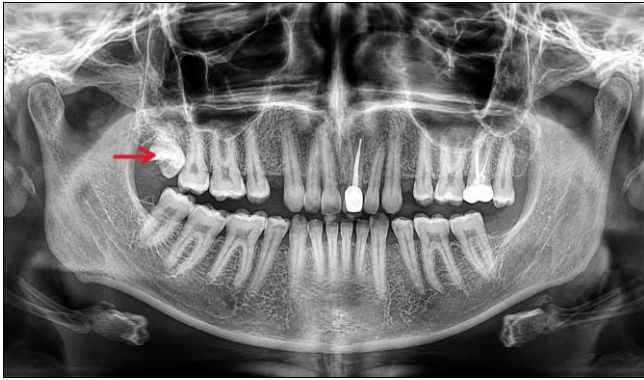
Panoramic radiograph showing an impacted maxillary right third molar with enlarged and irregular crown morphology and apparent absence of root formation
